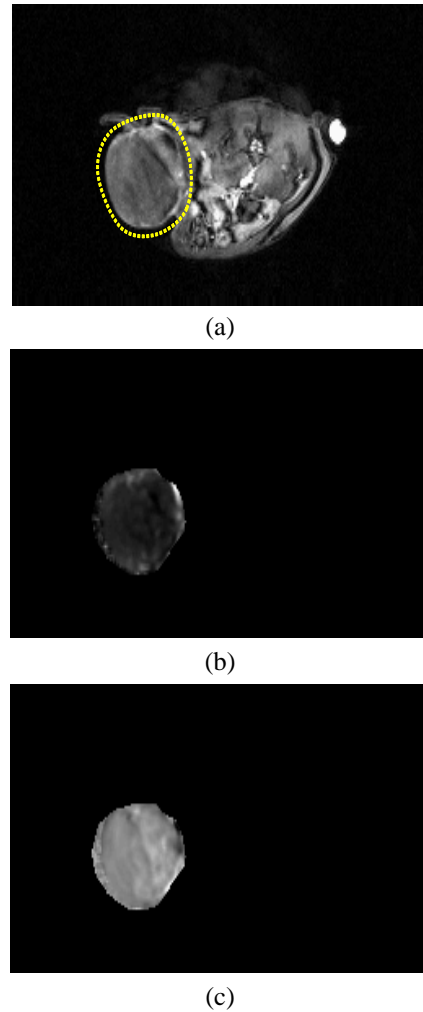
DEC-MRI: (a) example of MRI slice, where a contrast agent has been introduced into the tissue before the image acquisition; a rough section of the tissue was selected in order to apply our algorithm, highlighted by the dotted circle; (b) intensity image representing the fPV values; (c) intensity image representing the kPS values; in (b) and (c), the higher the values of the parameters, the brighter the color of the correspondent pixels.
